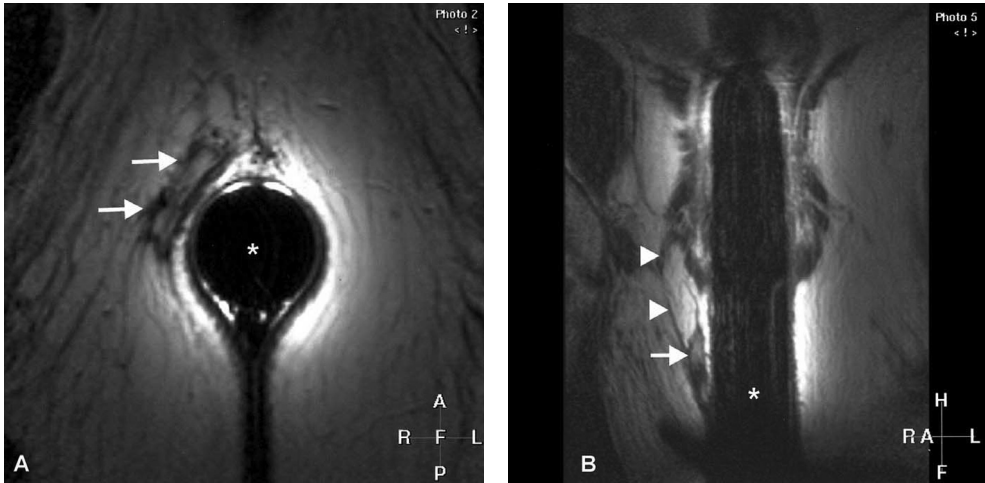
Subsphincteric fistula. Small fistula track is seen on the right (arrows). (A) Axial T2-weighted fast spin-echo (FSE) endoanal MR image (TR/TE = 2500/100 ms). (B) Coronal T2-weighted FSE image (TR/TE = 2443/100 ms). (B) Thin fibrous strand (arrowheads) is seen extending from the fistula to the sphincter muscles. Endoanal coil (*).
